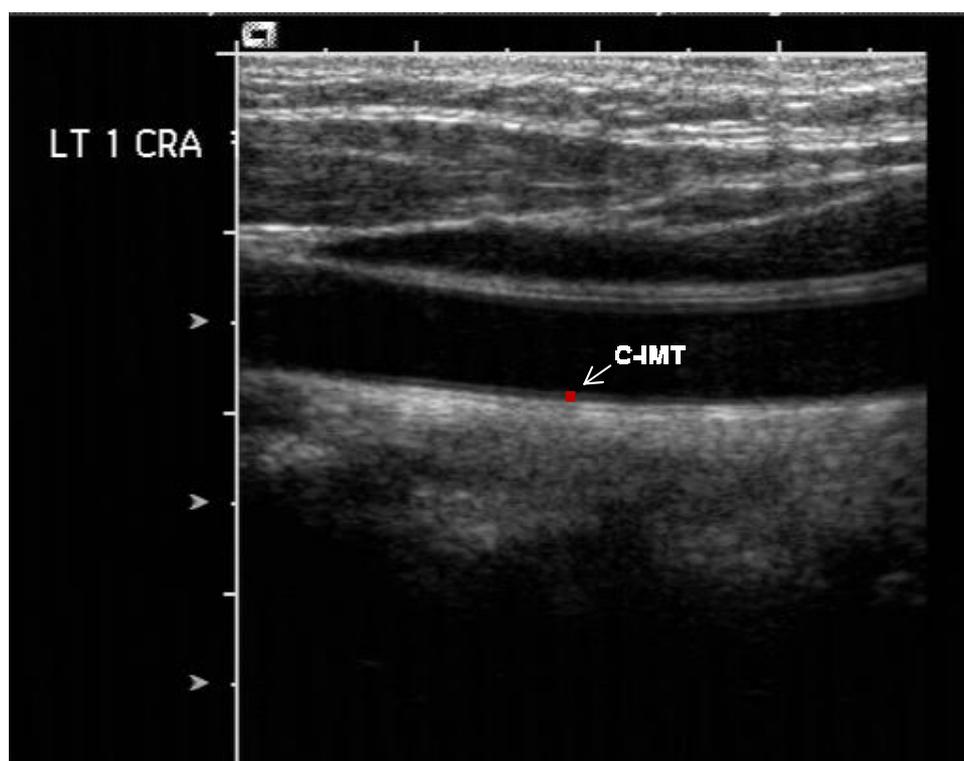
Ultrasound image indicating carotid artery intima-media thickness measurement site. C-IMT: carotid-intima media thickness
